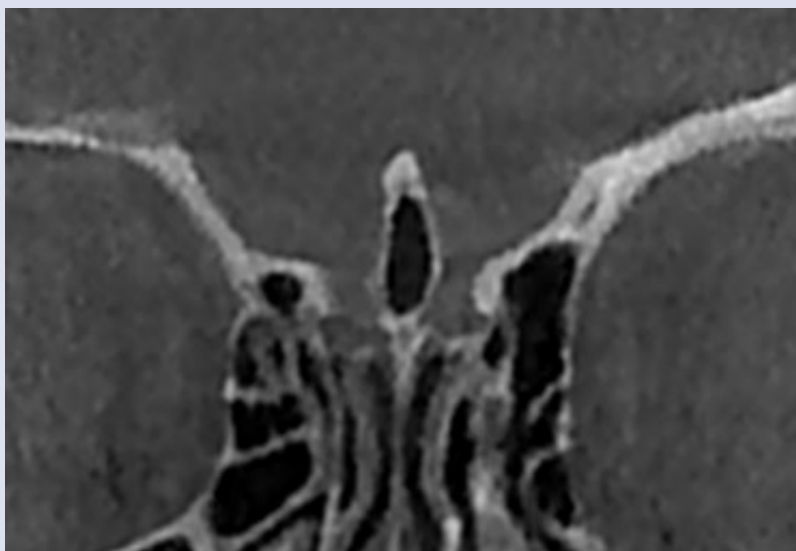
Pneumatized crista galli on coronal CBCT slice.
